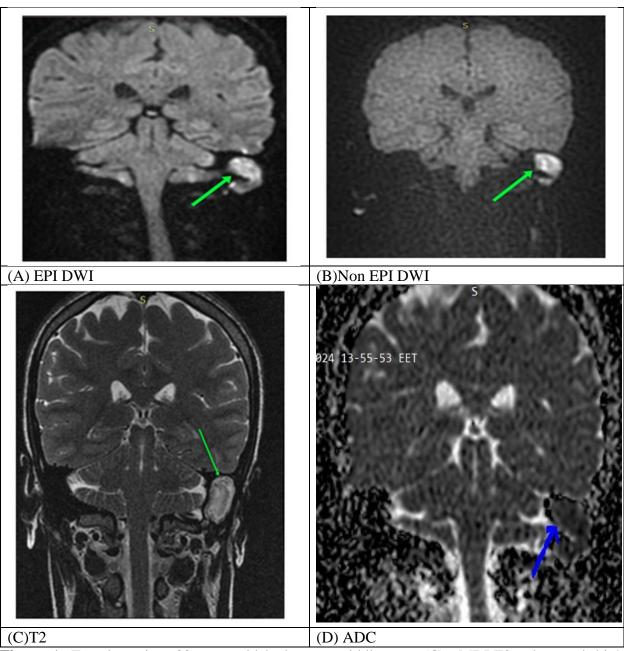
Female patient 30 years old had Cholesteatoma (A): EPI DWI: there is a lesion of increased signal intensity measuring 10x3mm on EPI- DWI and decreased signal intensity in ADC in left middle ear, (B): Non-EPI DWI: there is lesion of increased signal intensity measuring 8x3mm inNon-EPI DWI and decreased signal intensity in ADC in the left
